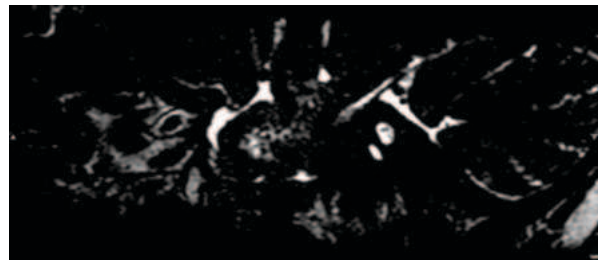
Sagittal T2W MR image showing absent cochlear nerve in same patient.
